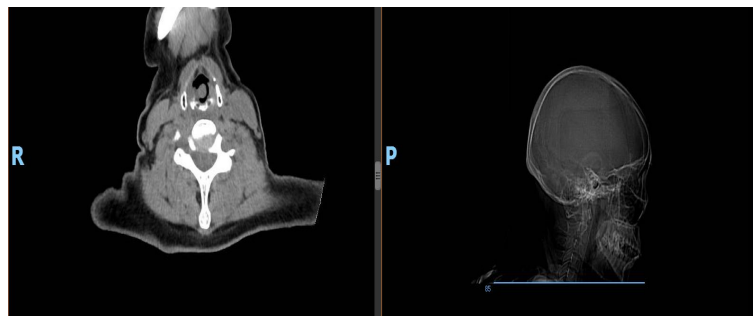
Computed tomography of the chest shows a localization in the vocal folds of the larynx. Computed tomography of chest cross-section.
